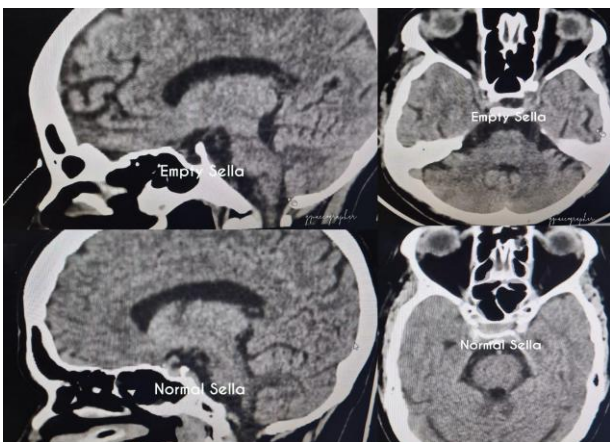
CT brain (sagittal and coronal views) showing an empty sella turcica (white text), consistent with pituitary necrosis.
